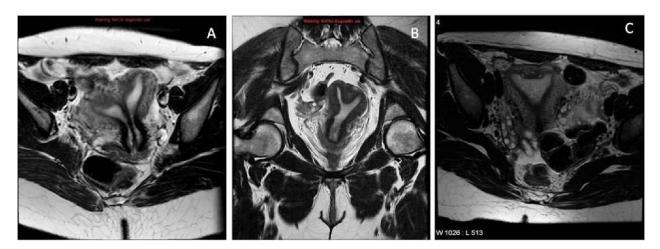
A: MRI image of complete septate uterus B: MRI image of incomplete septate uterus C: MRI image of the arcuate uterus
